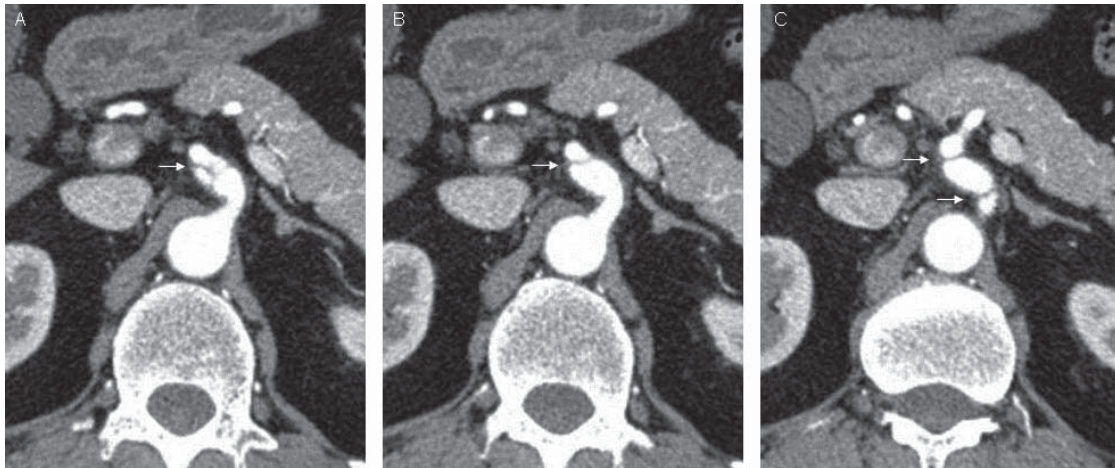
Contrast-enhanced CT images
